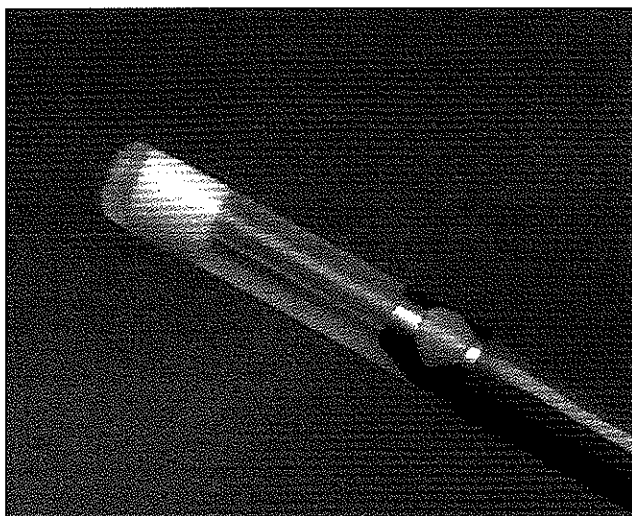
The ultrasound transducer, showing a distal sonolucent sheath, which houses the rotating echotransducer.
